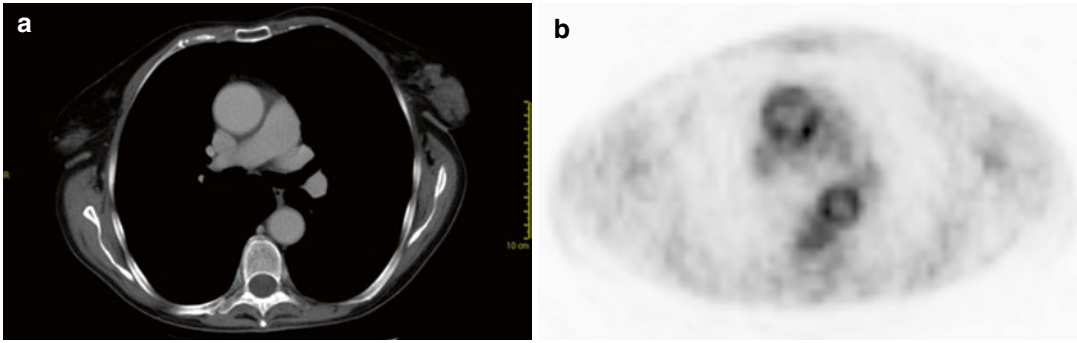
Axial CT (a) and PET (b) images of a patient with rheumatoid arteritis. There is questionable wall thickening of the normal caliber thoracic aorta at CT (a). PET
